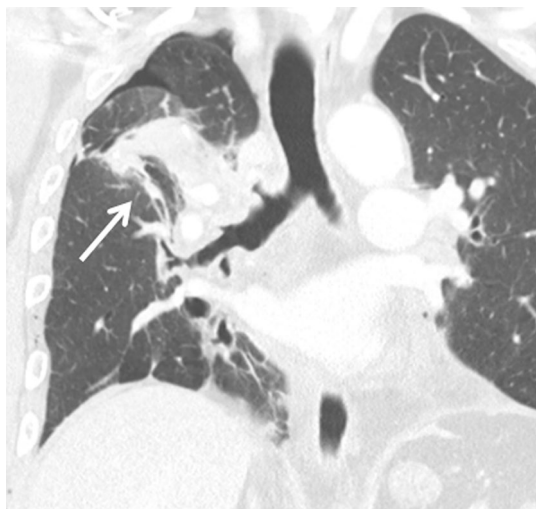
Postoperative atelectasis of a 60-year-old man who had undergone right upper lobectomy for adenocarcinoma and left lower lobe basal segmentectomy for synchronous adenocarcinoma. Coronal CT image on POD 1 shows wedge-shaped consolidation (arrow) with crowding of bronchovascular bundles in the right middle lobe and elevation of right major fissure
